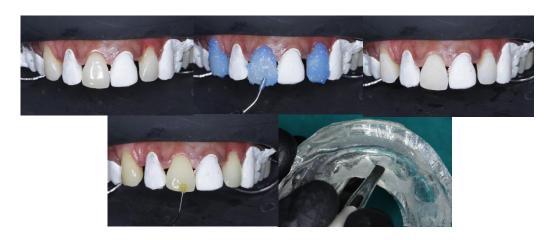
(10A,10B,10C,10D,10E) – ISOLATION OF ALTERNATE TEETH WITH TEFLON ie. 12,21,23, ETCHING, FROSTY WHITE APPERANCE OF ENAMEL, BONDING w.r.t. 13,11,22,APPLICATION OF MODELING RESIN ON THE INTAGLIO SURFACE OF INDEX RESPECTIVELY
